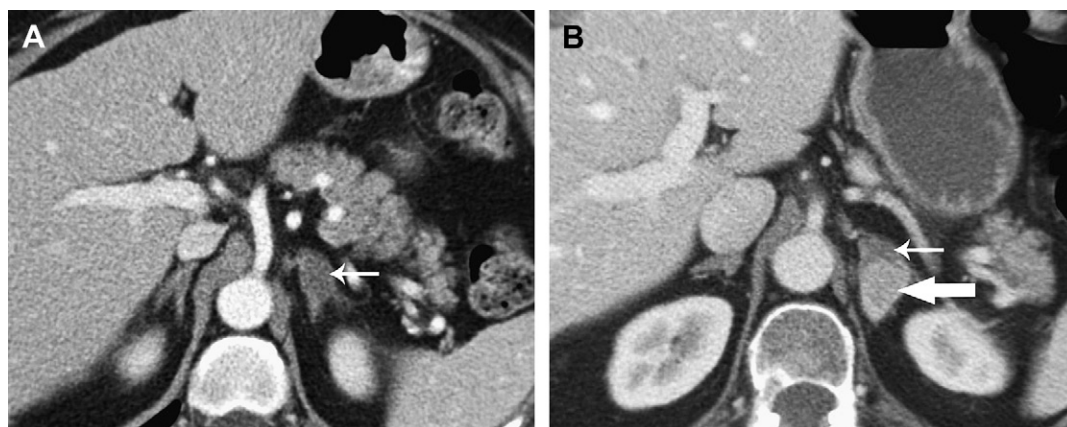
Value of comparing with prior examinations. (A) CT scan demonstrating a low-density benign adenoma (arrow). (B) CT scan 6 months later shows development of a new enhancing mass (large arrow) displacing the former adenoma (small arrow) (collision tumor).
